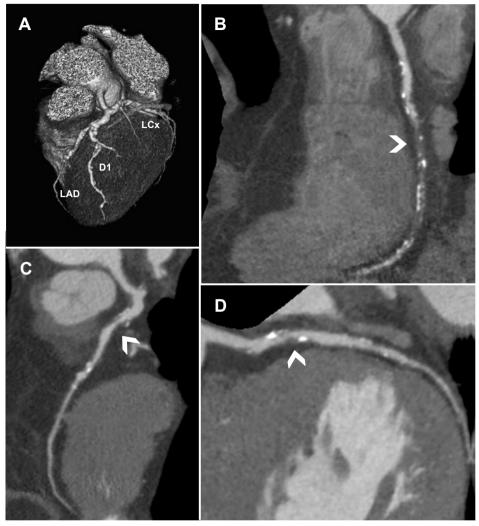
CTA of a 69 year-old man with type 2 DM and the hypertriglyceridemic waist phenotype revealing 3-vessel coronary disease. (A) Three dimensional volume rendered reconstruction of the heart giving an overview of the LAD, D1 and LCx. (B) Multiplanar reconstruction of the RCA revealing a total occlusion with calcified and non-calcified plaque (arrow). (C) Multiplanar reconstruction revealing a severe lesion in the proximal LAD (arrow). (D) Multiplanar reconstruction showing a severe lesion in the proximal LCx (arrow) with non-calcified and calcified plaque components.
